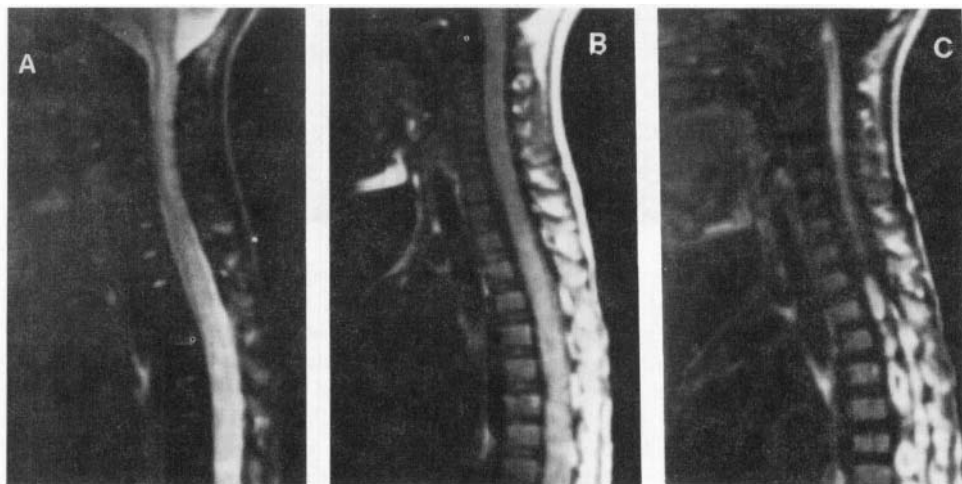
Intramedullary abscess. T2-weighted sagittal image (a) of the cervicothoracic spine shows swollen cord with hyperintensity especially in the thoracic part. T1-weighted image (b) shows heterogeneous, predominantly hyperintensity of the thoracic part of the cord. Postcontrast image (c) shows multiple rim enhancing areas in the thoracic and cervical cord suggestive of multiple intramedullary abscesses. Pus aspirated was positive for *Staphylococcus aureus*.
